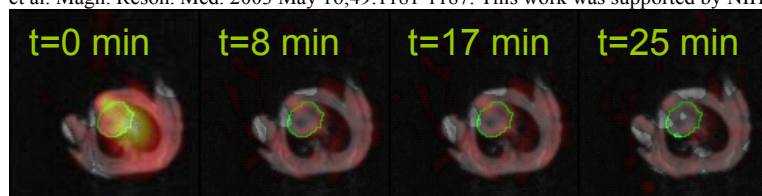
EPRI superimposed over the MRI for a slice through heart (green contour).
